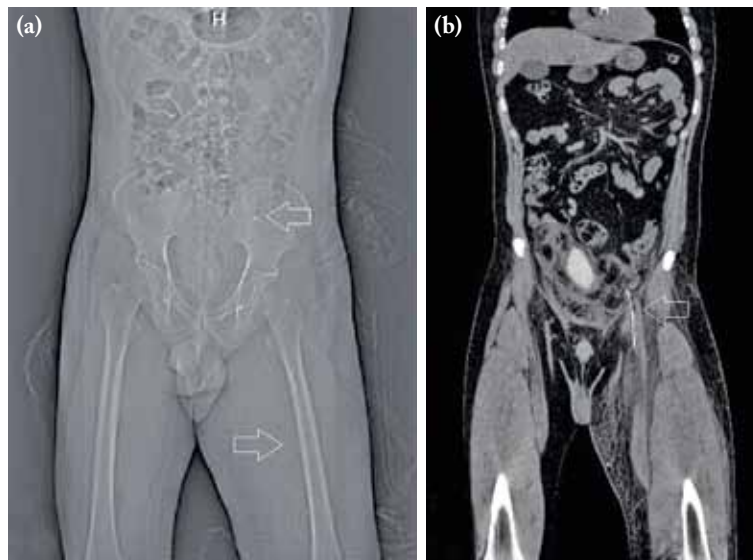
Plain anteroposterior roentgenogram showing the course of the EKOS EndoWave catheter. (a) Note the upper arrow that points to the extravasated tip of the catheter. (b) The computed tomography is showing a segment of the EKOS EndoWave catheter inside the iliac vein.
